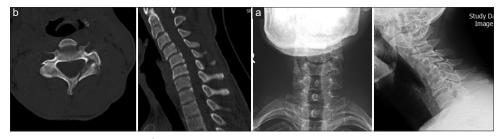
(a) Lateral and AP plain radiograph. (b) Sagittal reconstruction and axial computed tomography; computed tomography images shows fracture in the laminae and pedicle of C4 vertebra, plain radiograph only shows mild antrolisthesis at C4-C5 level and reverse kyphosis in lateral view
